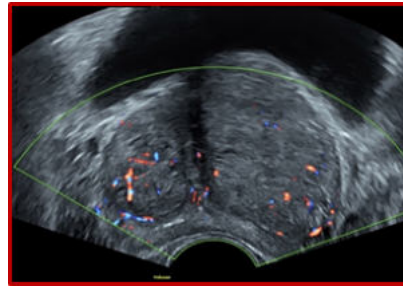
a: Transabdominal ultrasound showing enlarged transitional zone
